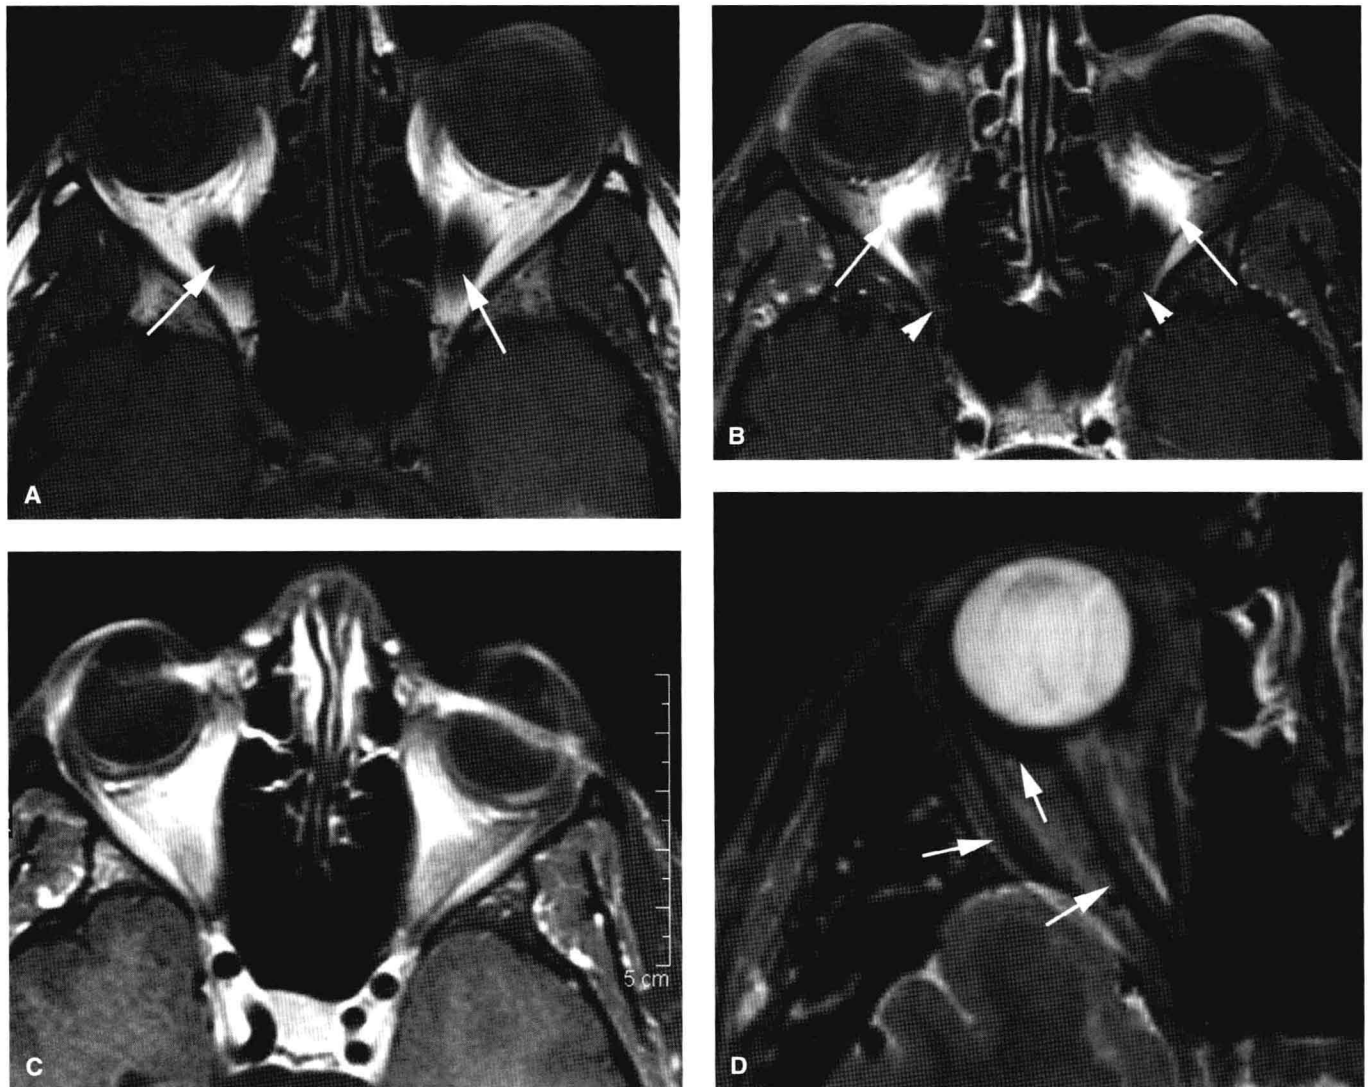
Artifacts as seen on magnetic resonance imaging of the orbit. A, B: The field distortion artifacts seen along the floor of the orbit (arrows in A) become much exaggerated in the fat suppression image (arrows in B). The field distortion artifacts that are much worse in (B) also obscure the anatomy at the orbital apex (arrowheads). C: Field distortion artifacts due to permanently placed eyeliner as a tattoo. D: Water-fat shift artifact (arrows).
